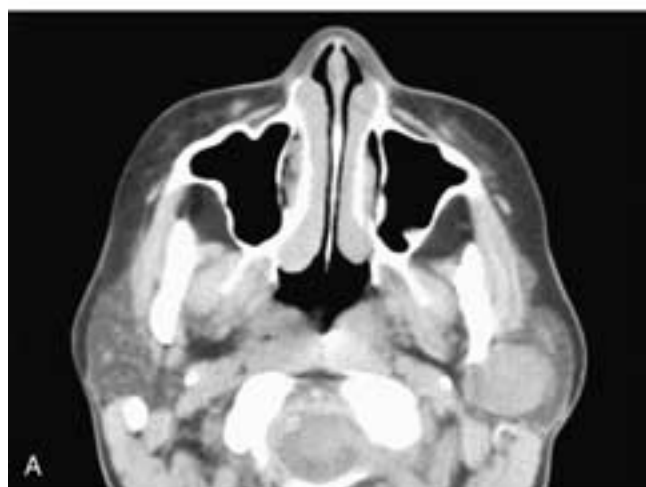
Axial CT scans on three different patients. In A, there is a homogeneous, spherical, sharply outlined mass in the left parotid gland. In B, there is a smooth homogeneous mass in the right parotid gland. In C, there is a smooth homogeneous mass in the deep portion of the left parotid gland. In both A and B, the mass is near the course of the facial nerve, although more of the mass is in the deep portion of the gland. The tumor was superficial to the nerve in A and B and deep to the nerve in C. All three patients had pleomorphic adenomas.
